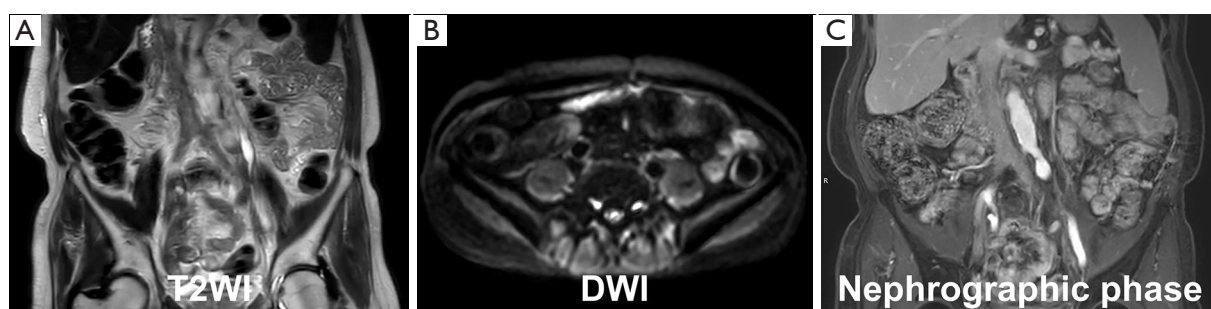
Magnetic resonance urography imaging of ureteral DSRCT after chemotherapy and intensity-modulated radiotherapy. (A-C) T2WI, T2-weighted imaging; DWI, diffusion-weighted imaging; DSRCT, desmoplastic small round cell tumor; fat-sat Gd-T1WI, fat-saturated gadolinium-enhanced T1-weighted imaging.
